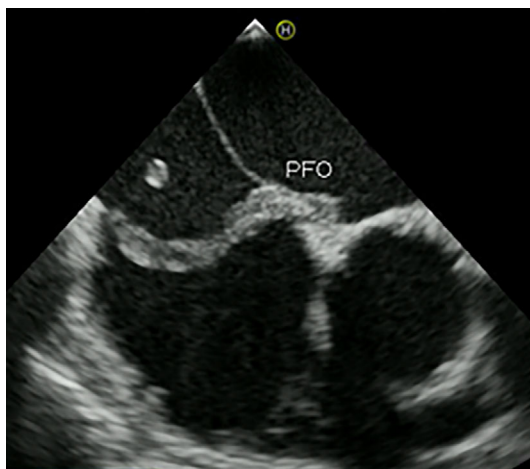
Transesophageal echocardiography showing a mobile thrombus entrapped in PFO. PFO: patent foramen ovale
